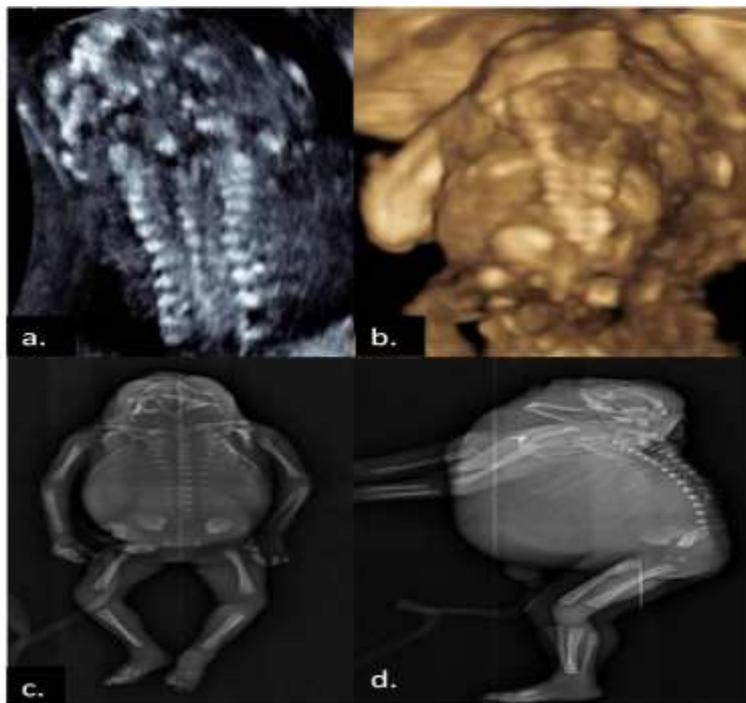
a (Coronal section spine) b (3 D Image) c and d (Radiograph of abortus AP and Lat. views) showing absence of cervical vertebrae and rachischisis of upper thoracic vertebrae.
